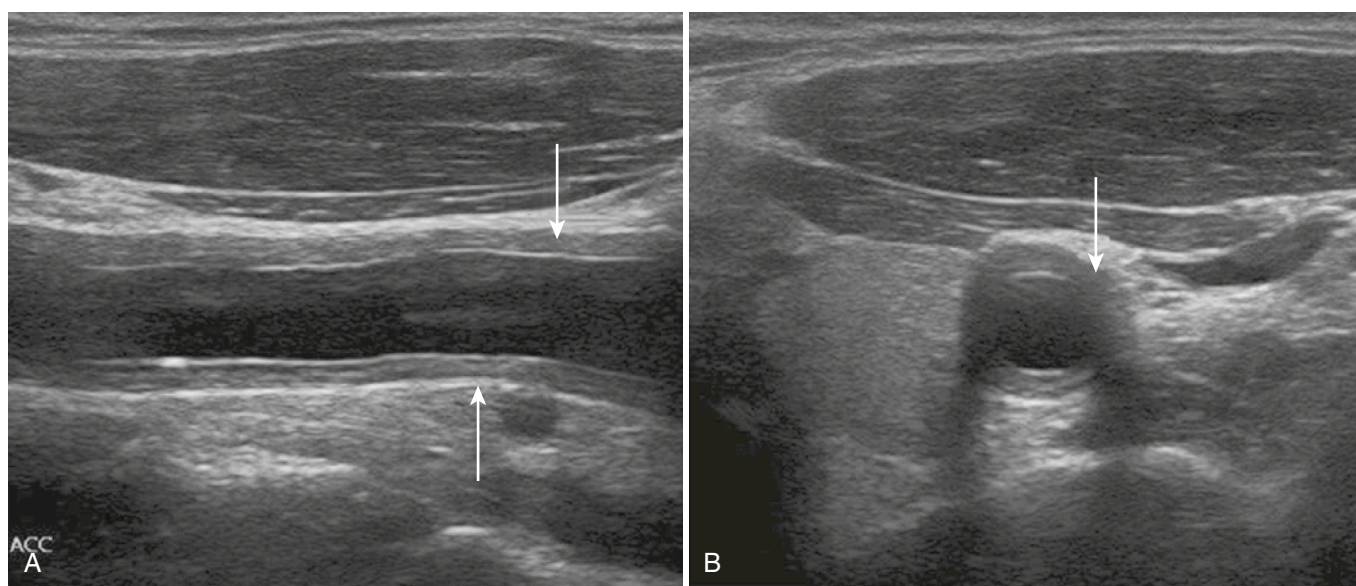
Longitudinal (A) and transverse (B) views show the common carotid artery in a patient with Takayasu's arteritis. The hyperechoic, homogeneous wall swelling (arrows) is visible even without the use of color Doppler mode.
